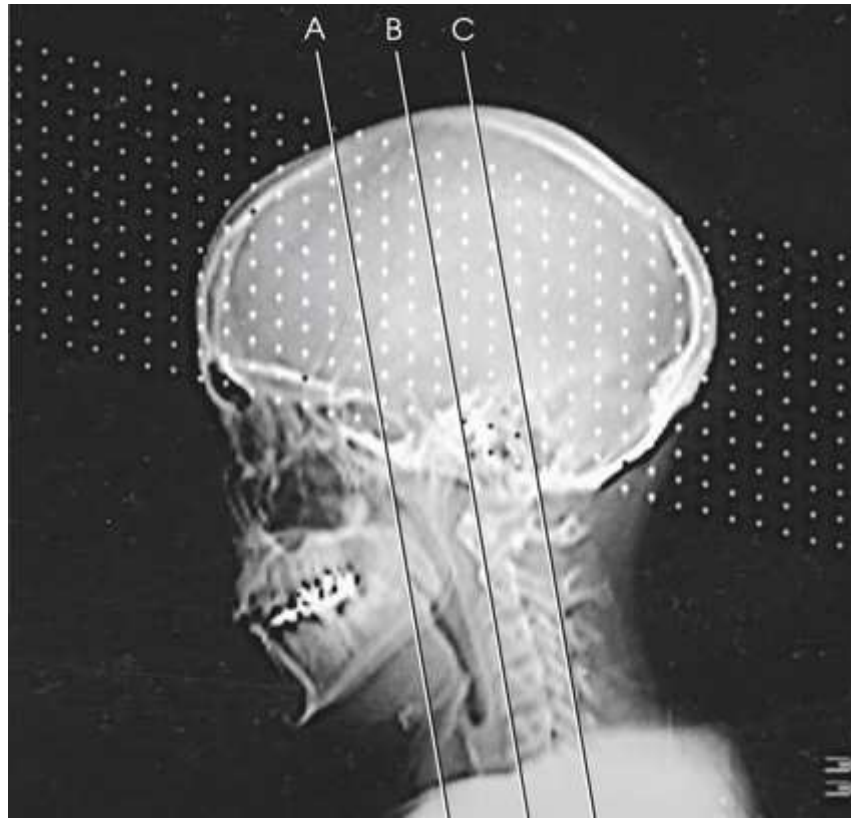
CT localizer (scout) image of skull.
